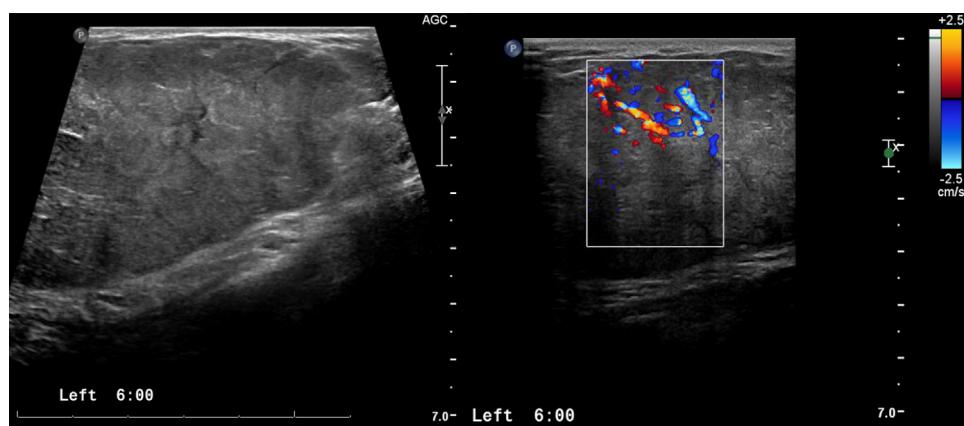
Ultrasound image of $10.0 \times 8.0 \times 4.3$ cm left breast mass. Note the Doppler flow within the mass.
